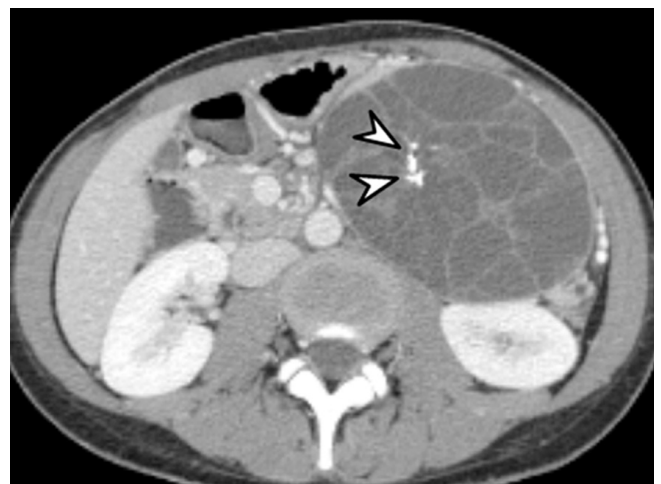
Mucinous cystic neoplasm of pancreas in 31-year-old female. Axial contrast-enhanced CT image demonstrates large, well-defined, low-attenuated cystic mass with multiple internal septa in pancreatic tail (not shown). Typical septal calcifications (arrowheads) are noted within lesion. Distal pancreatectomy was performed, and mucinous cystic neoplasm was diagnosed.
